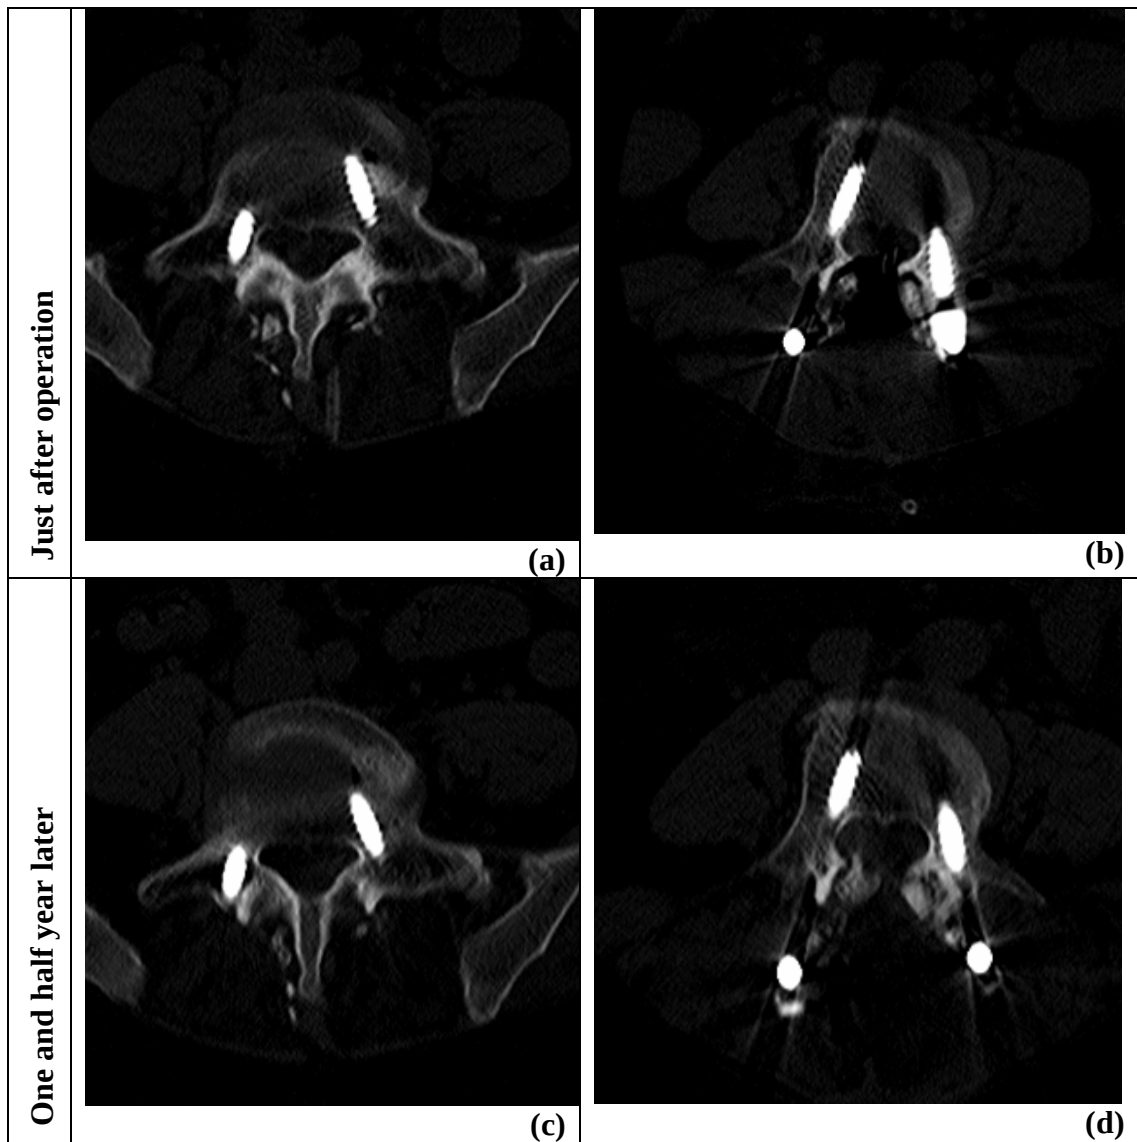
Radiograph of density distribution of pedicle screw lumbar vertebrae. (a,b) Just after operation. (c,d) One and half year later.
